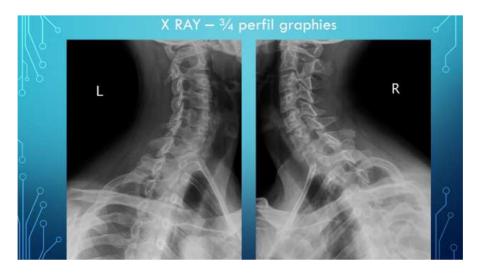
X-ray of the cervical spine – Collier profiles
